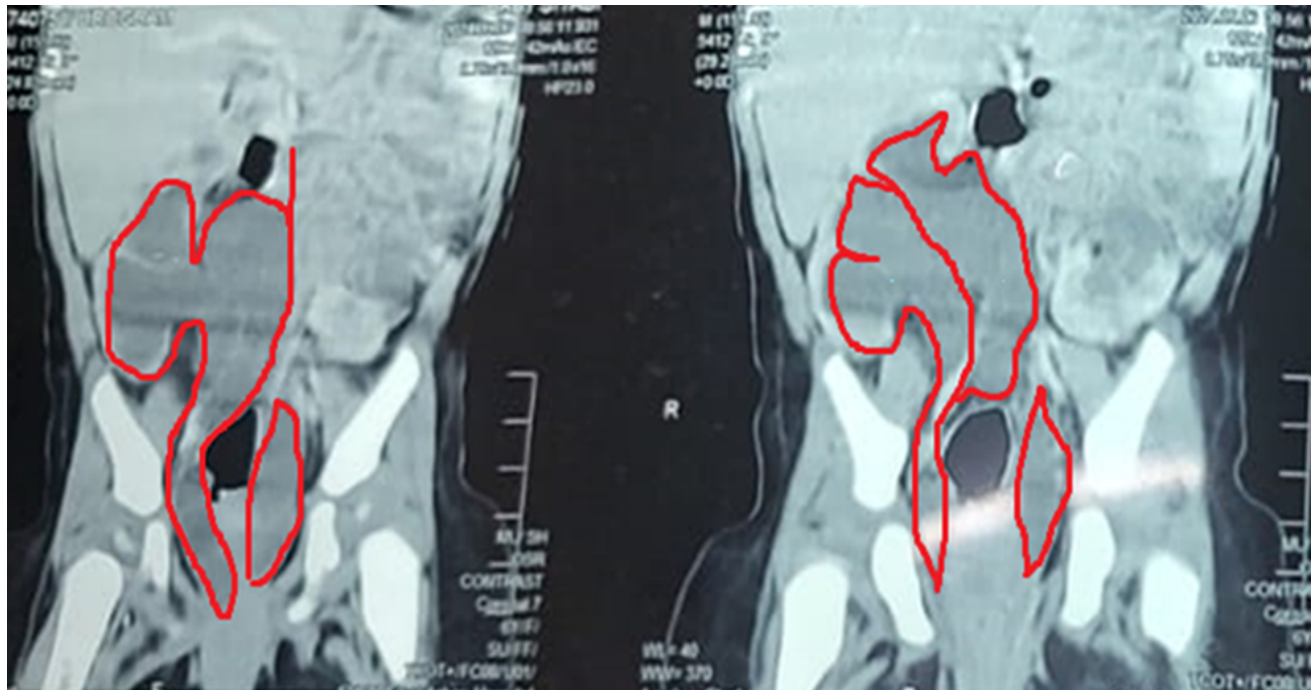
CT Urogram showing enlarged and hydronephrotic kidneys with partial duplex system on right side. Lower end of the ureters can be appreciated at the level bladder neck and urethra. Both ureters are dilated and tortuous; left placed more medially.
